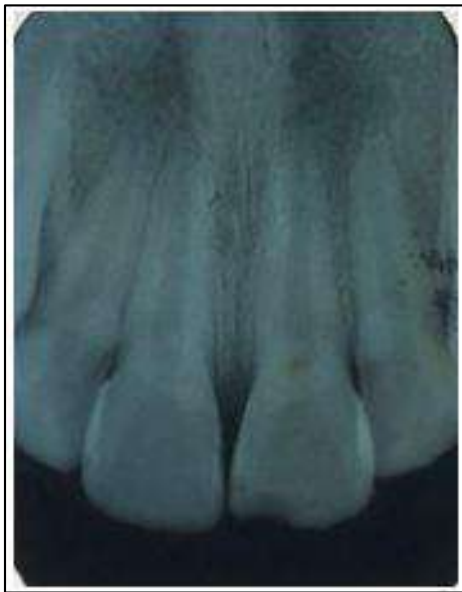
Periapical Dental
